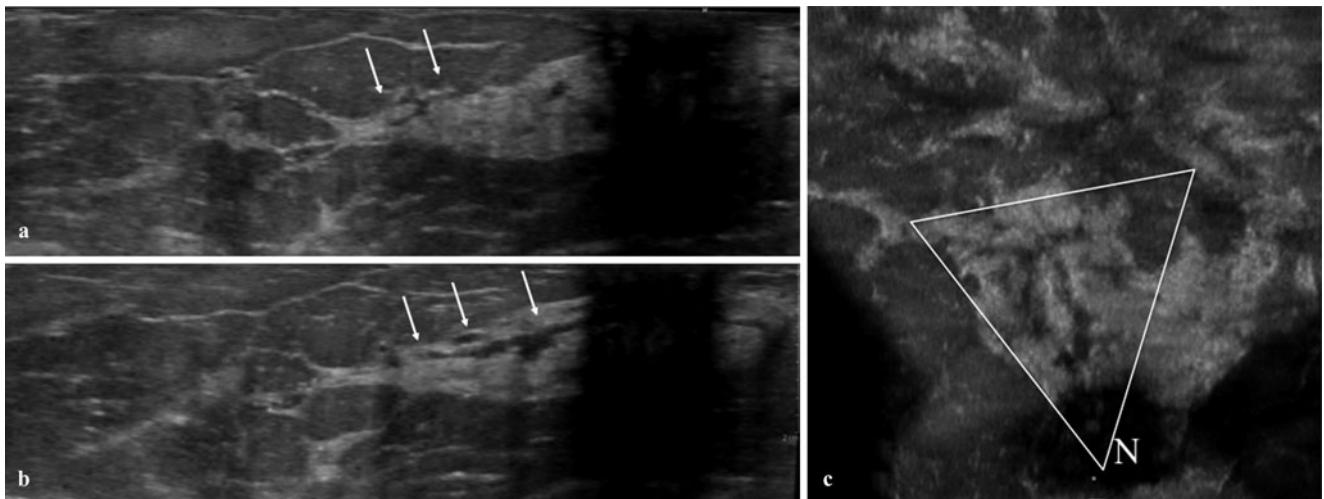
A 39-year-old woman had invasive ductal carcinoma with an extensive intraductal component. A Axial reconstruction image of automated ultrasonography (US) shows arborization of the ducts (*arrows*) in the upper-outer quadrant of the right breast. B Axial reconstruction image of automated US shows ductal extension (*arrows*) in the subareolar area. C Coronal reconstruction
